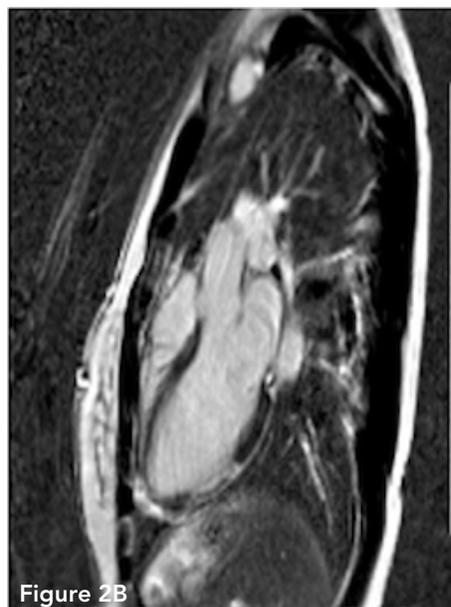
A) Cardiac magnetic resonance imaging (CMR) with segmented phase sensitive inversion recovery. The three-chamber view revealed a left ventricular ejection fraction of 51%, left ventricular mid-posterior wall akinesia, and late gadolinium enhancement. B) Repeat CMR 3 months later. LVEF was 53% and persistent left ventricular mid-posterior wall akinesia were observed.
